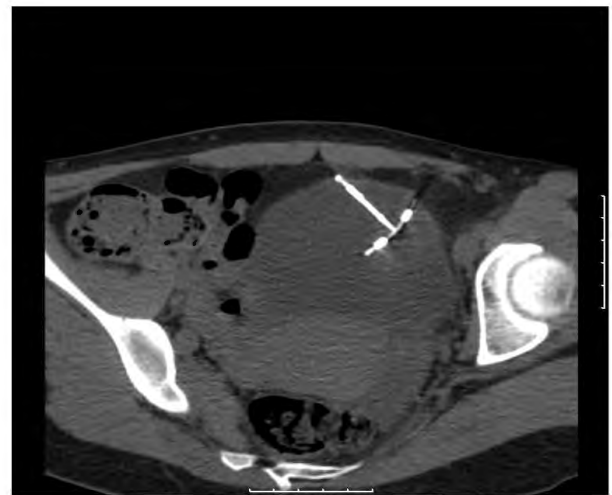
Image of migrated IUD in CT section.
